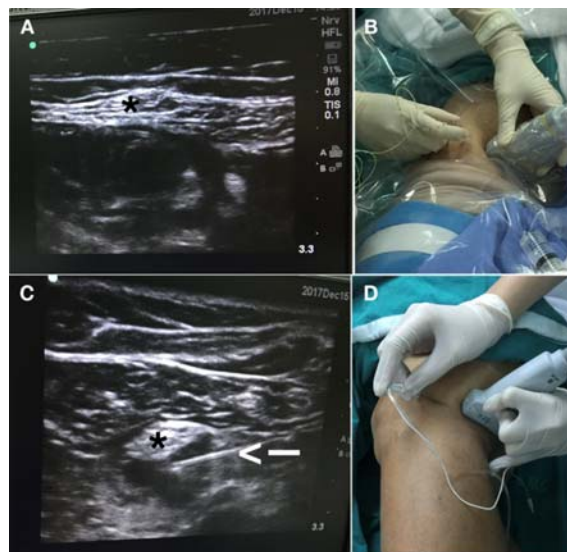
A) Cross-sectional ultrasonography image of the adductor canal. Bupivacaine (0.15%; 15 ml) was infiltrated around the saphenous nerve (asterisk). B) Continuous adductor canal block. C) Cross-sectional ultrasonography image of the posterior tibial fossa. Bupivacaine (0.25%; 15 ml) was infiltrated (arrow) around the tibial nerve (*). D) Posterior tibial nerve block.
